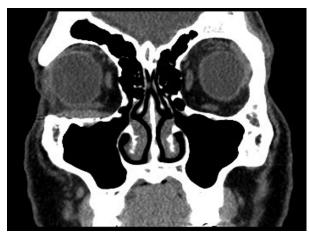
Preoperative coronal computed tomogram view demonstrating cystic lesion superior to the orbital floor implant. Preoperative computed tomogram sagittal view demonstrating inadequate posterior orbital floor fracture reduction.
